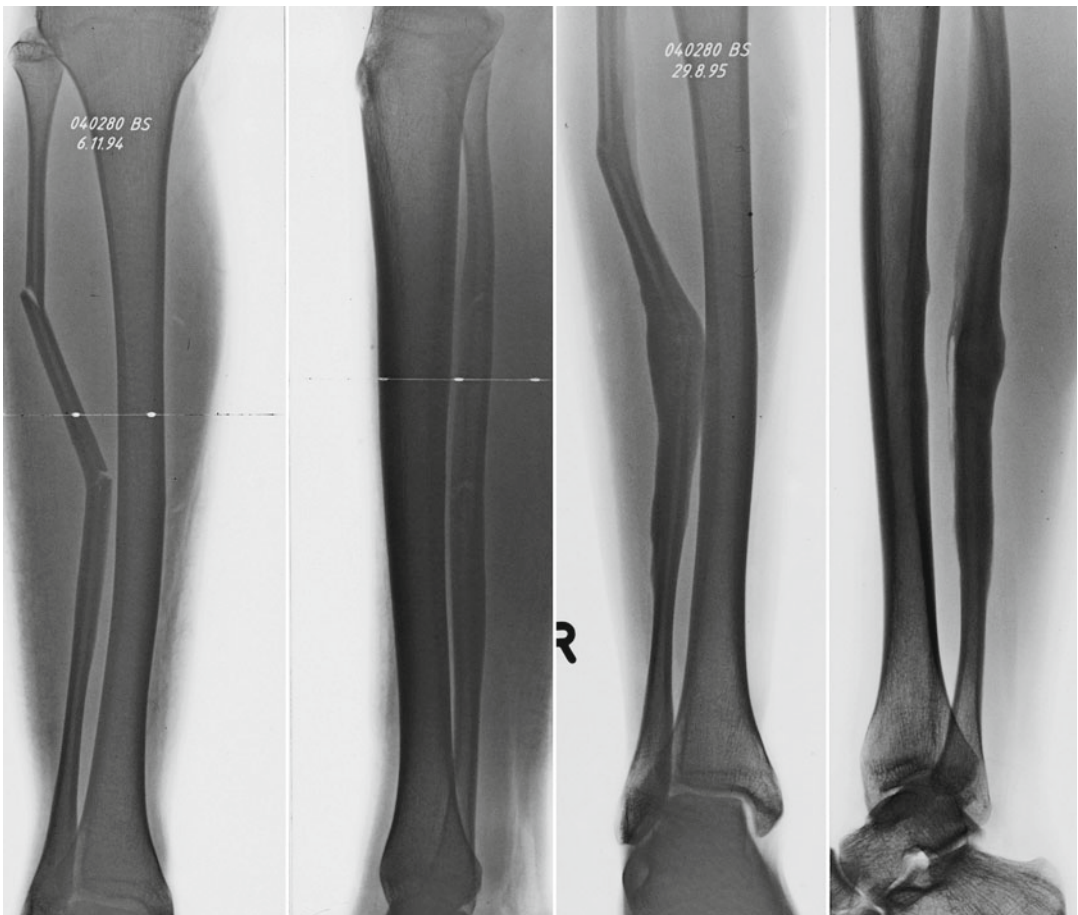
Direct lower leg trauma in a 15-year-old boy with “bowing” fracture of the tibia. The x-rays show a malunion 8 months after this “bowing fracture” of the tibia (still remaining bowing)
